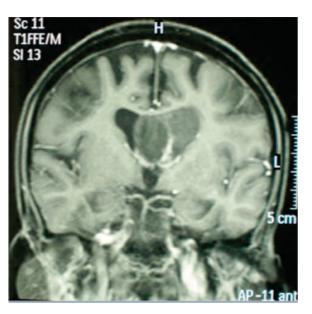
Coronal computed tomography corneal magnetic resonance imaging cut in contrast showing a solid-cystic intraventricular lesion with 2.8 cm of cranial caudal length.
